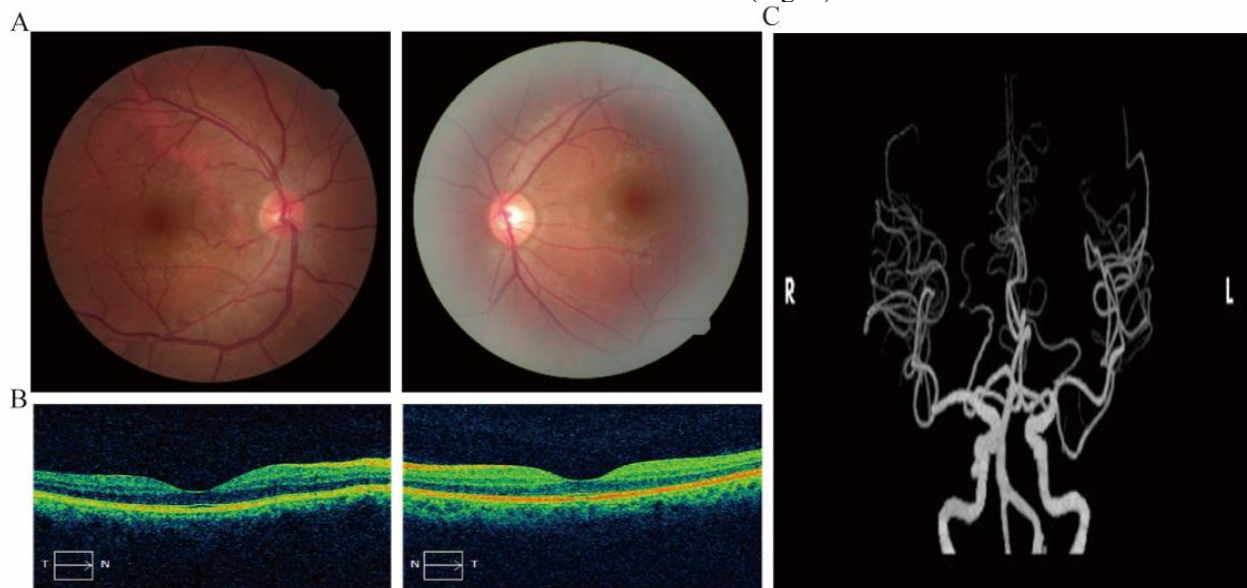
Case 4 –CRVO-like retinal venous stasis secondary to CCF. (A) Color fundus photographs show retinal venous dilation and mild congestion in the right eye, with normal appearance in the left eye. (B) OCT reveals preserved macular contour bilaterally. (C) CTA confirms a right-sided carotid-cavernous fistula involving the cavernous sinus.
